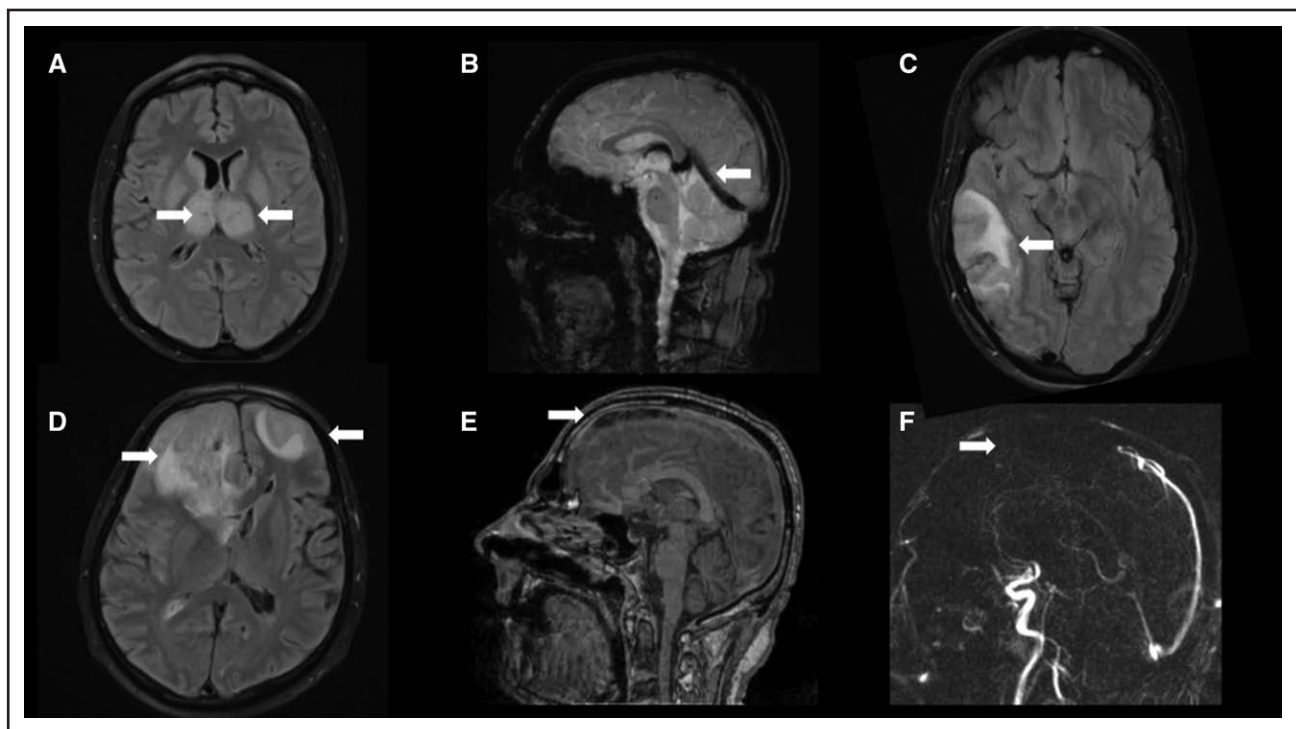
Typical findings of cerebral venous thrombosis on magnetic resonance imaging.
